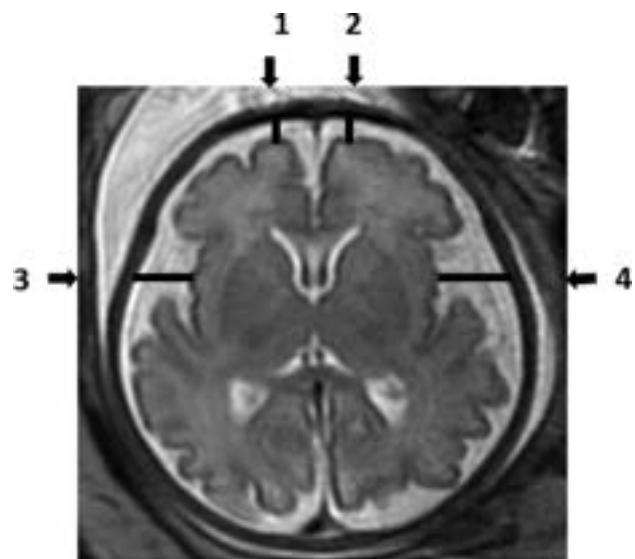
Axial T2-weighted fetal brain image demonstrating the measurements of the subarachnoid space: 1) Right frontal gyrus. 2) Left frontal gyrus. 3) Right insula gyrus. 4) Left insula gyrus.
